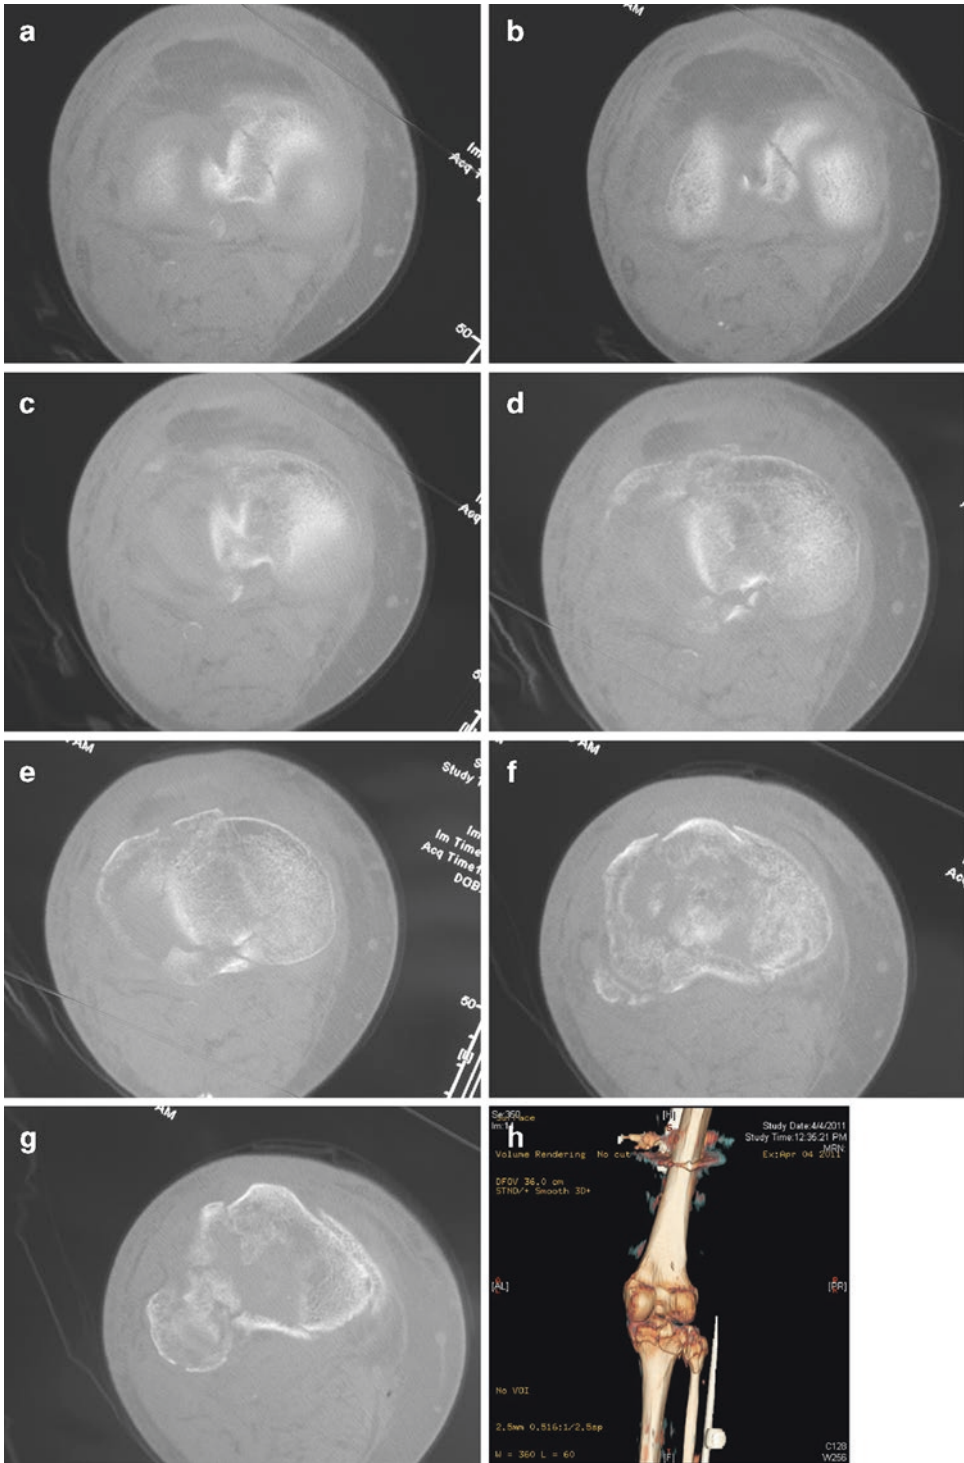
(a–g) Axial CT proximal tibia. (h) 3 D CT proximal tibia
